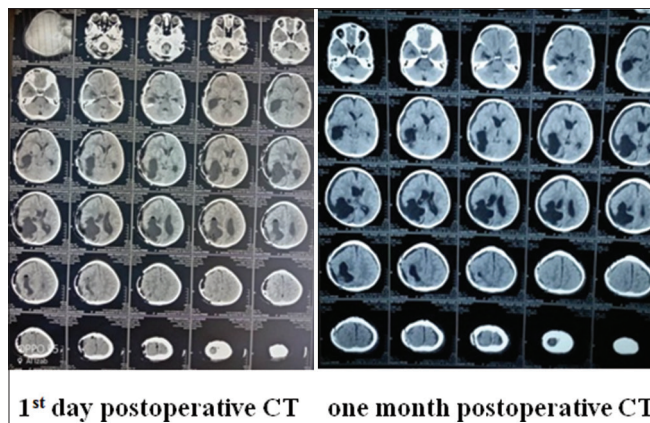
Postoperative computed tomography brain in the first day and after 1 month.
